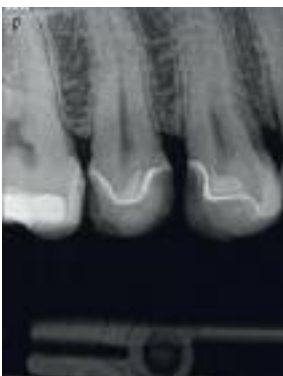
A, B Radiograph A. six months and B. 1 year post-treatment.
